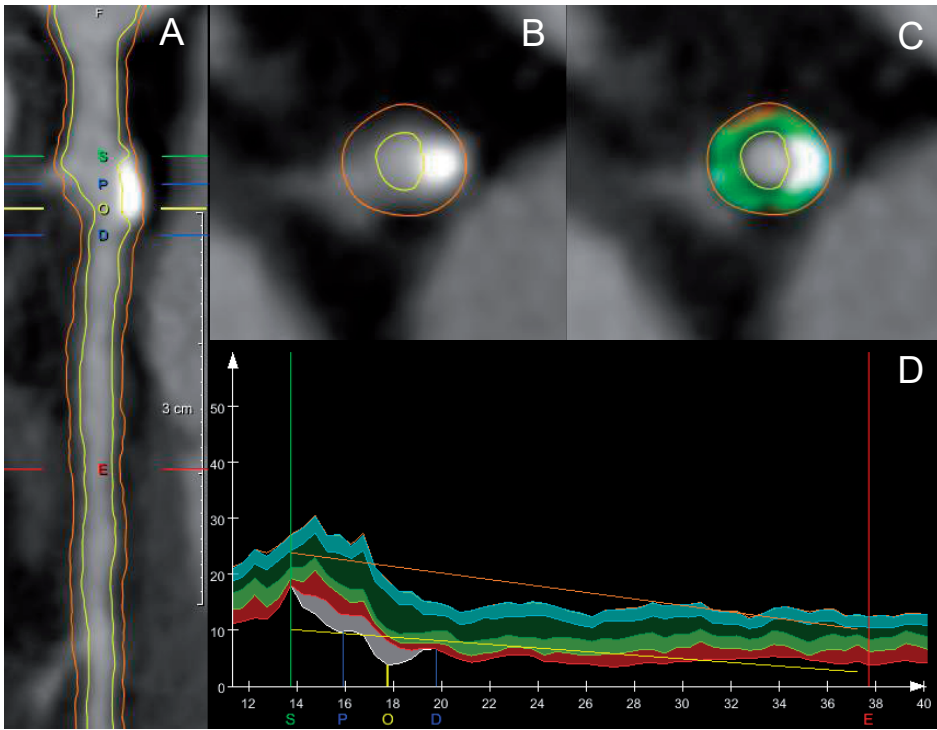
Example of quantitative CTA analysis of a 48 year old male patient referred for the evaluation of stable chest pain.
